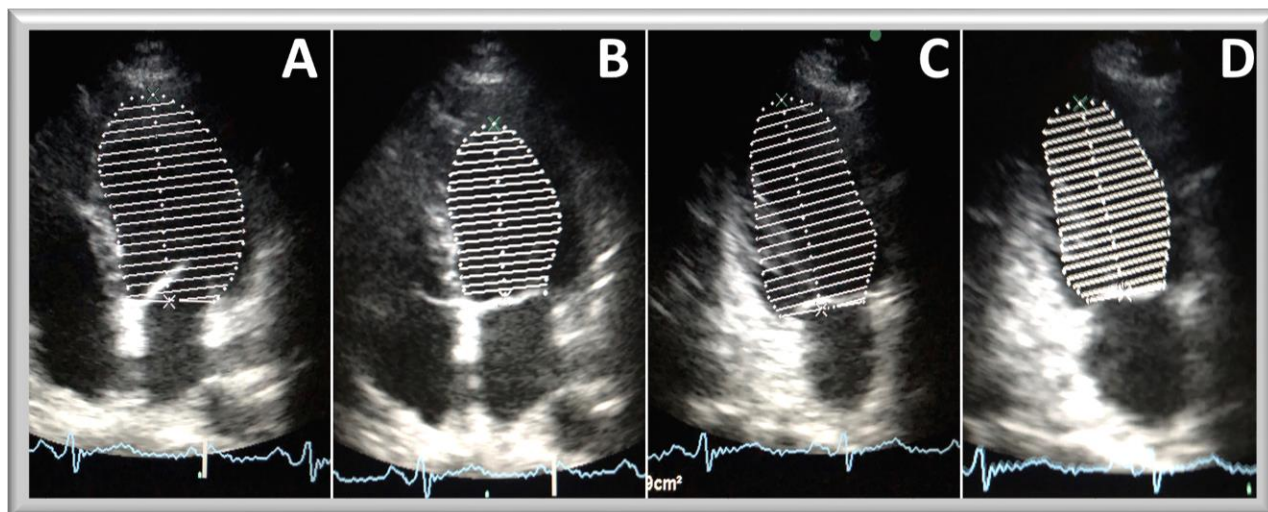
LVEF estimation by Bi-plane Simpson's method. A and B apical 4 chamber views, C and D apical 2 chamber views.
